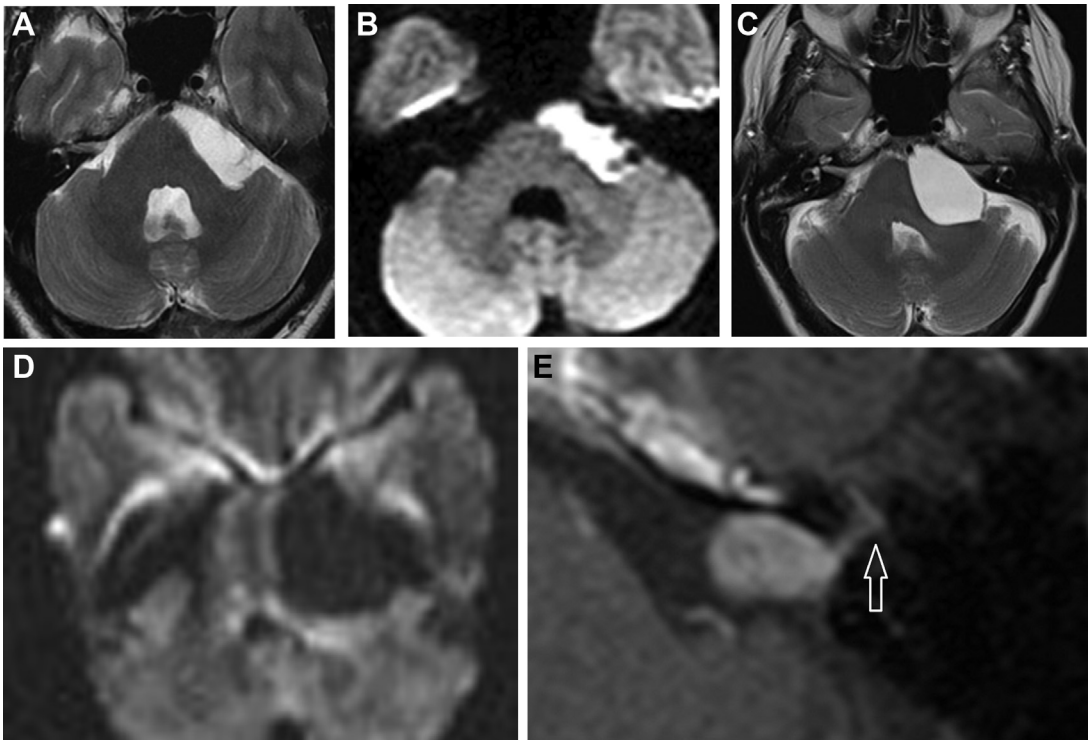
Imaging differential diagnosis of CPA mass. (A) T2w axial and (B) DWI depict a CPA epidermoid and characterized by increased DWI as compared to (C) T2w axial and (D) DWI images of a CPA arachnoid cyst. (E) Post-gadolinium T1w axial image identifies a facial schwannoma by its tail of enhancement in the line of the nerve (arrow).
